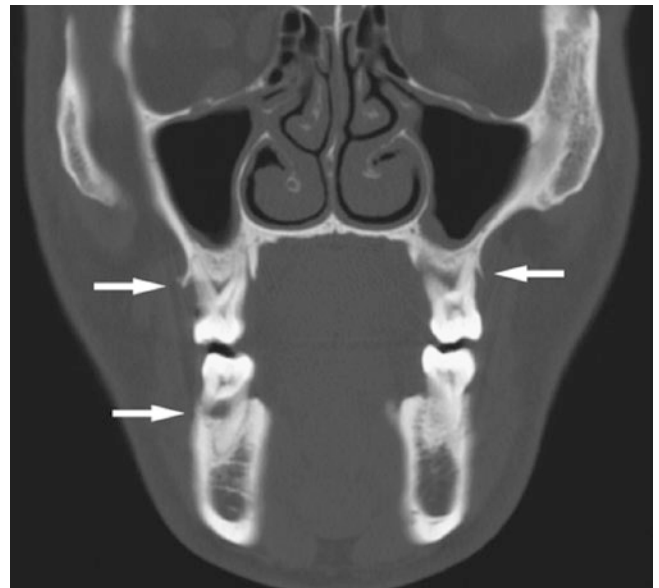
Periodontal disease; 35-year-old male with incidental finding. Coronal CT image shows destruction of alveolar bone in the maxilla and mandible with loss of periodontal bone support in bifurcation of mandibular molar roots and trifurcation of maxillary molar roots (*arrows*); left maxillary molar has no remaining bone support of palatal “floating” root
